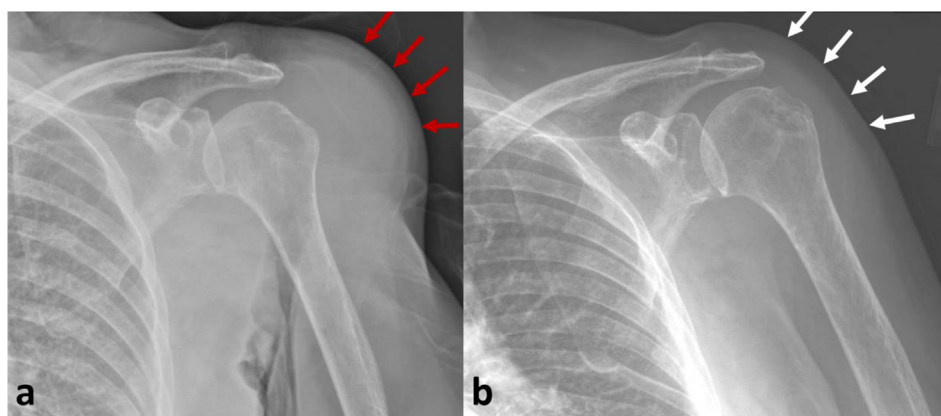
Anteroposterior (AP) plain radiographs of the patient's left shoulder. 1a shows the initial radiograph taken on first visit, a week after COVID-19 vaccination. It demonstrates significant soft tissue swelling over the deltoid region (annotated with red arrows). 1b shows the interval radiograph taken three months post injury, showing resolution of soft tissue swelling, corresponding with the recovery from shoulder synovitis and effusion (annotated with white arrows). (For interpretation of the references to colour in this figure legend, the reader is referred to the web version of this article.)
